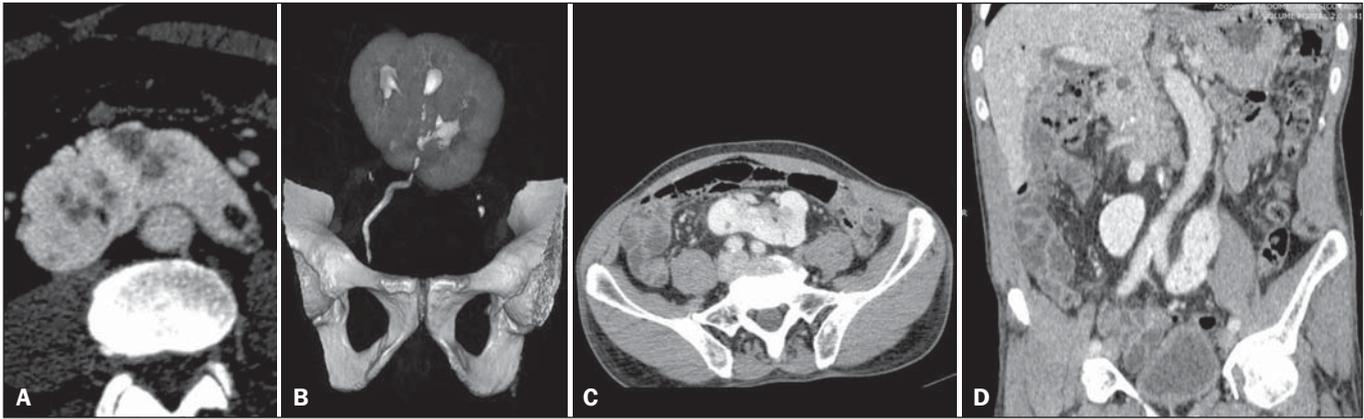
A: Axial CT image of the abdomen in the arterial phase showing pancake kidney with cysts. B: Three-dimensional CT reconstruction of the abdomen (excretory phase) showing a single ureter. C,D: Axial CT images and coronal CT reconstruction of the abdomen (portal phase), showing a single, flat, medial, non-reniform mass, at the level of the aortic bifurcation.
